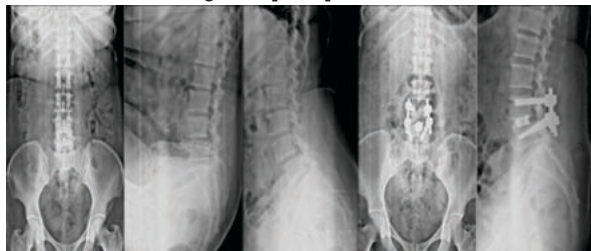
Preoperative & Postoperative Radiographs
